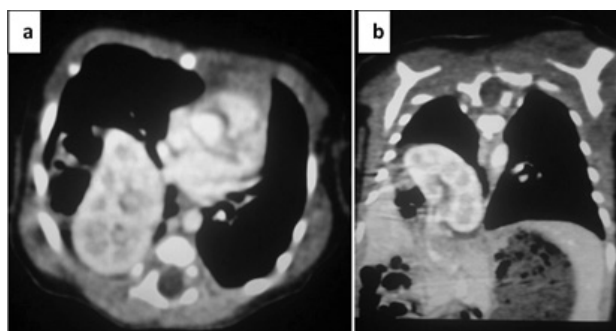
CT chest: (a) Axial view showing a right diaphragmatic hernia with intrathoracic bowels and right kidney (b) coronal reconstruction showing the diaphragmatic defect and herniation of right kidney and bowels into the thoracic cavity.
